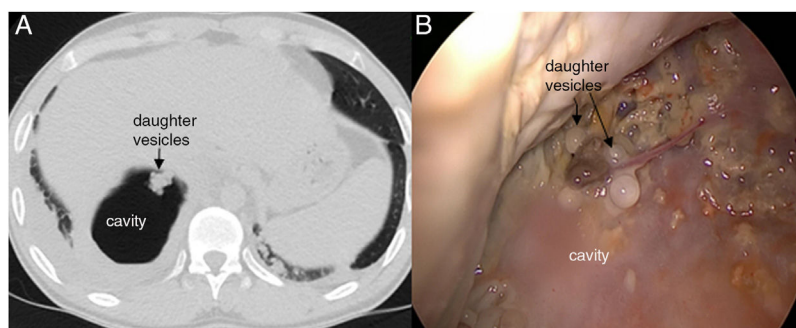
(A) Thorax computed tomography shows the appearance of “grape cluster appearance”. (B) Daughter’s vesicles were seen.
